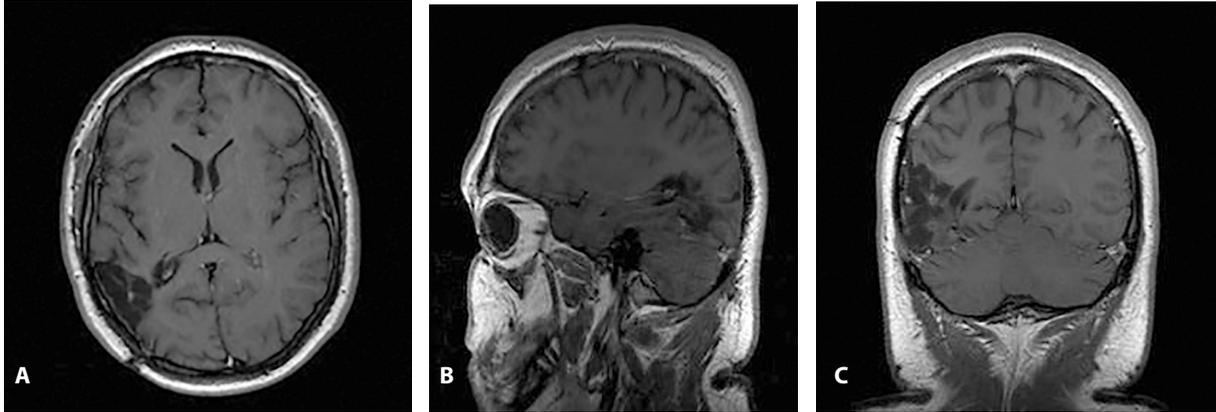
Postoperative axial (A), sagittal (B), and coronal (C) MRI.
